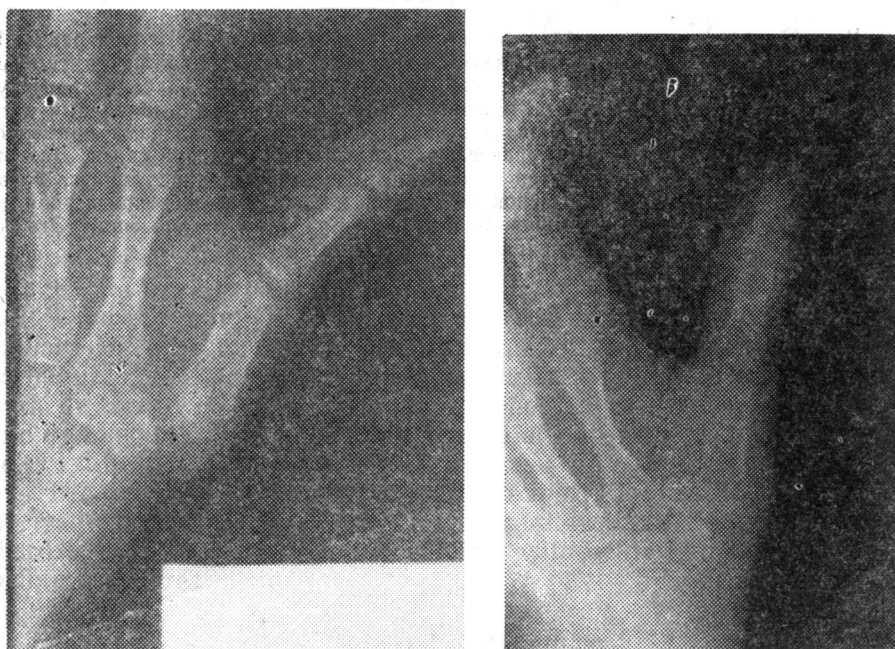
X-rays investigation of the habitual luxation of the first CMA before and after operation
